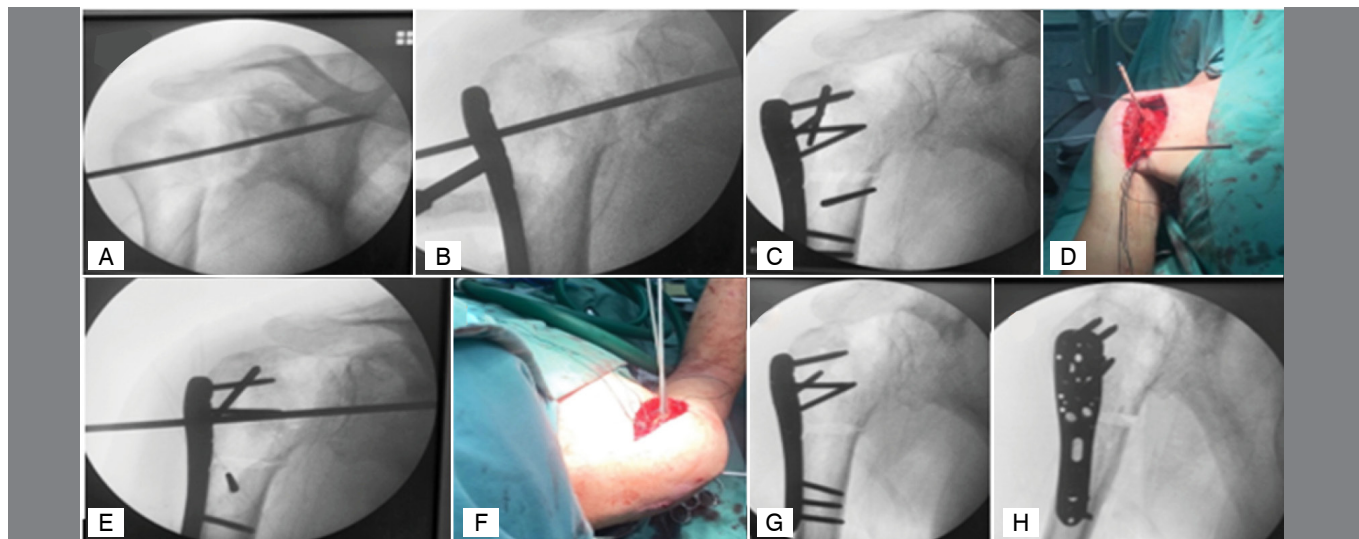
Reduction of the humeral head (A) and fixation in the glenoid with a temporary 3.0 mm wire; placement of the locked plate and fixation with proximal screws (B); placement of temporary k-wires with 30° between them (radiological image - C and clinical positioning - D) Osteotomy and external rotation of the arm of 300 (radiological image E clinical image F where parallelism between the k-wires is observed; fixation of the locked plate completed and removal of k-wires (radiograph in anteroposterior position G and lateral view H).
